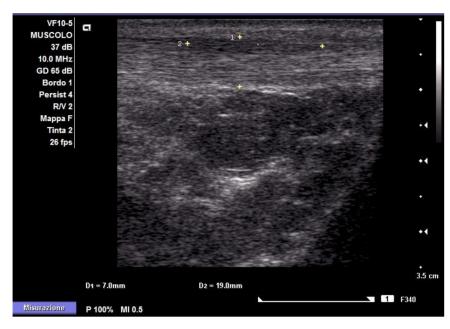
AT Ultrasound Scan
